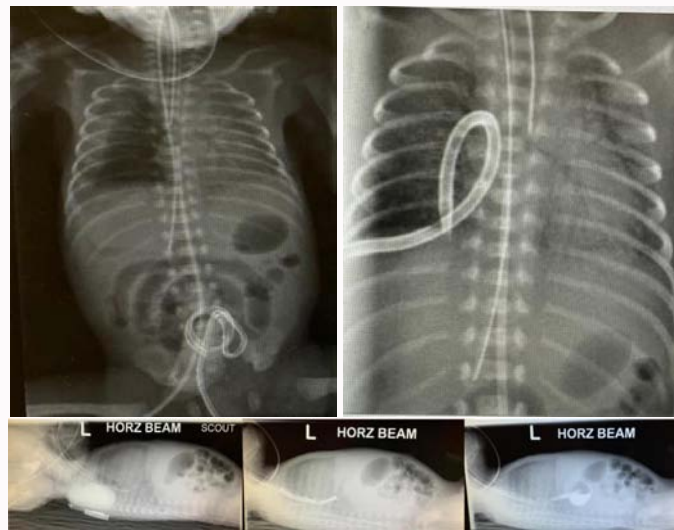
5a) CXR showing right pneumothorax and malposition of feeding tube. 5b) CXR taken after pigtail catheter insertion with resolution of right pneumothorax. Case 12: Contrast study was done in the Neonatal Intensive Care Unit instead of the fluoroscopy room, which was the usual practice, due to COVID-19 restrictions limiting movement of patients within the hospital, and the risk of transfer of the extremely preterm infant who was still ventilated. The contrast study was done with the tip of the feeding tube placed at the junction of the mid and distal thirds of the esophagus, under direct laryngoscopic visualization. Water soluble contrast was gently hand injected through the feeding tube and both trans-lateral and frontal chest radiographs were obtained. There was unimpeded flow of contrast in the distal esophagus, gastro-esophageal junction, then stomach and finally into duodenum (5c). No false passage of contrast was seen, particularly in the region of suspected distal esophageal perforation, suggestive of healed esophageal perforation. This case supports a nonoperative approach for the management of neonatal esophageal perforation and demonstrates how the contrast esophagogram can be carried out in the NICU instead of the fluoroscopy room, which was standard practice previously.
